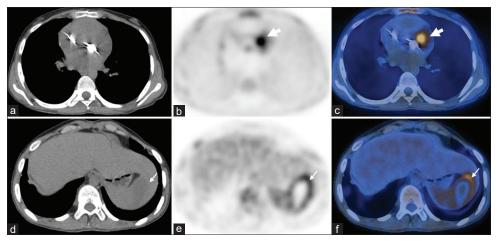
Top row: Axial noncontrast CT (a) ¹⁸F-FDG PET (b) and fused PET/CT (c) images showing increased FDG uptake anterior to the prosthetic mitral valve (bold white arrows). Bottom row: Axial noncontrast CT (d) ¹⁸F-FDG PET (e) and fused PET/CT (f) images demonstrating a hypodense lesion with no significant FDG uptake in the spleen (white arrows), indicating a splenic infarct. ¹⁸F-FDG PET/CT: 18F-Fluorodeoxyglucose positron emission tomography/ computed tomography
